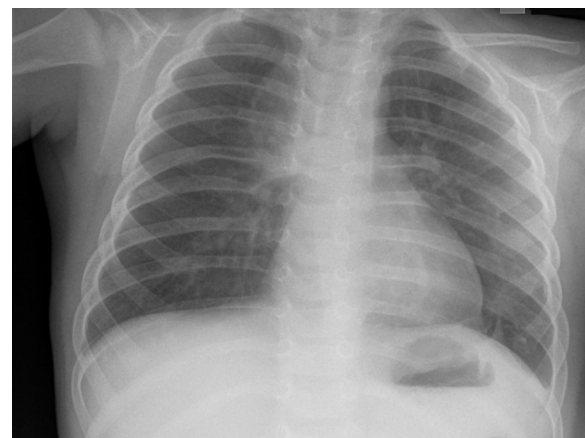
Chest X-ray at 10 months of age showing a good surgical result.
